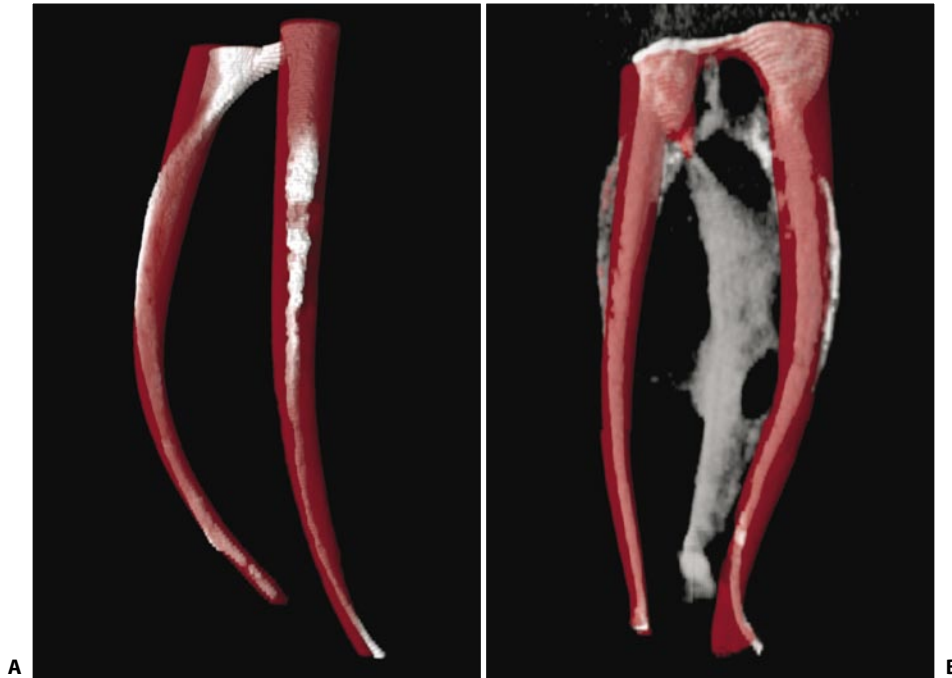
A, B. μ CT reconstructions of mesial canals of mandibular molars with white indicating original canal paths and transparent red showing final shapes with landed-flute GT Files on left and non-landed-flute ProTaper Files on right. Note lack of ProTaper shapes.
